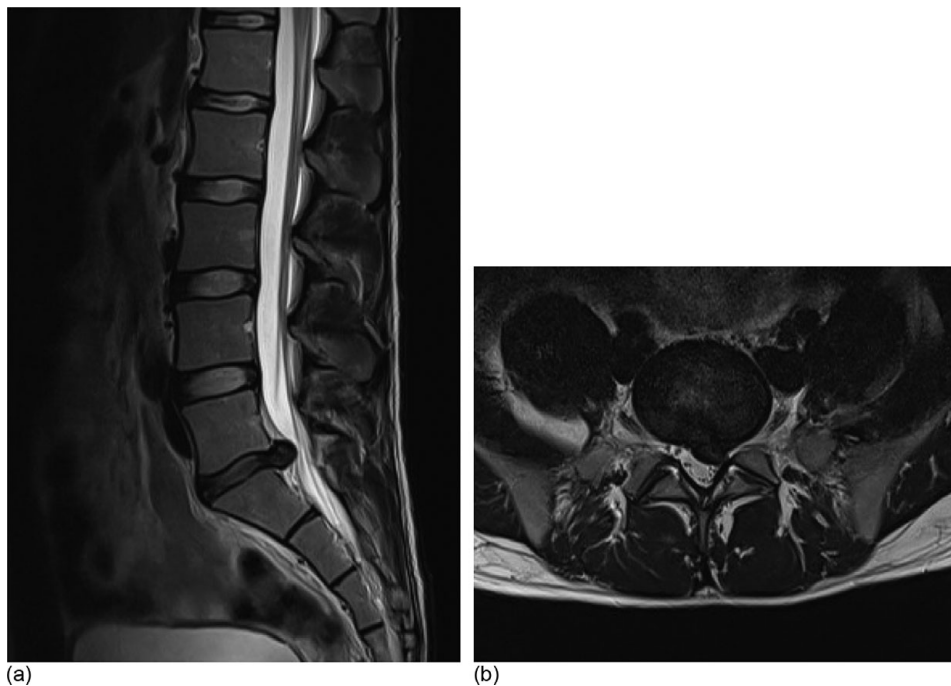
(a) Sagittal T2 and (b) axial T2 at L5/S1 level MRI images lumbar spine
